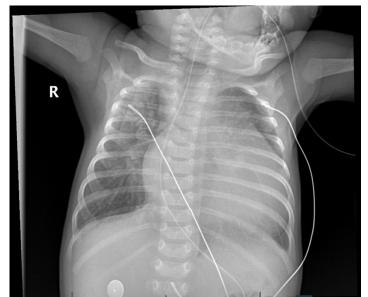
Chest radiograph demonstrating cardiomegaly and interstitial prominence suggestive of pulmonary edema.
